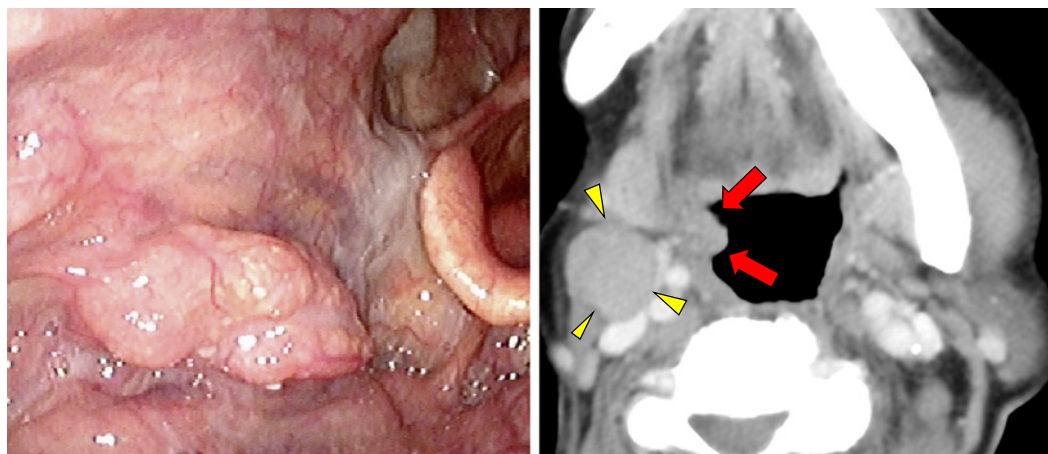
Endoscopic findings and contrast-enhanced computed tomography. Endoscopic findings: tumor on the anterior wall of the mid-pharynx. Contrast-enhanced computed tomography: tumor in the anterior wall of the mid-pharynx, with no infiltration of the parapharyngeal space (red arrow). The right upper internal deep cervical lymph node was enlarged (yellow triangle).
